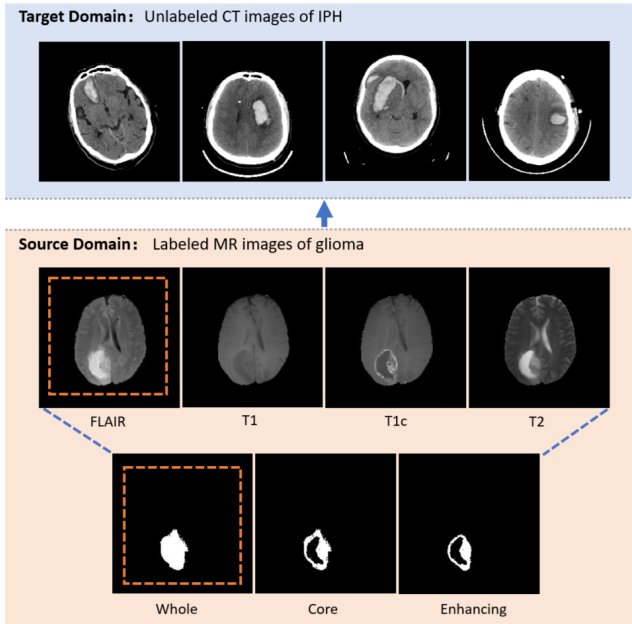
These two datasets span different image modalities (MRI and CT) and diseases (glioma and IPH), which is a tough challenge. In our task, we choose FLAIR modal MRI and a label covering the entire tumor as the source domain data pair (marked with the red dashed boxes). The bright circular stripes in CTs are CT head holders.
